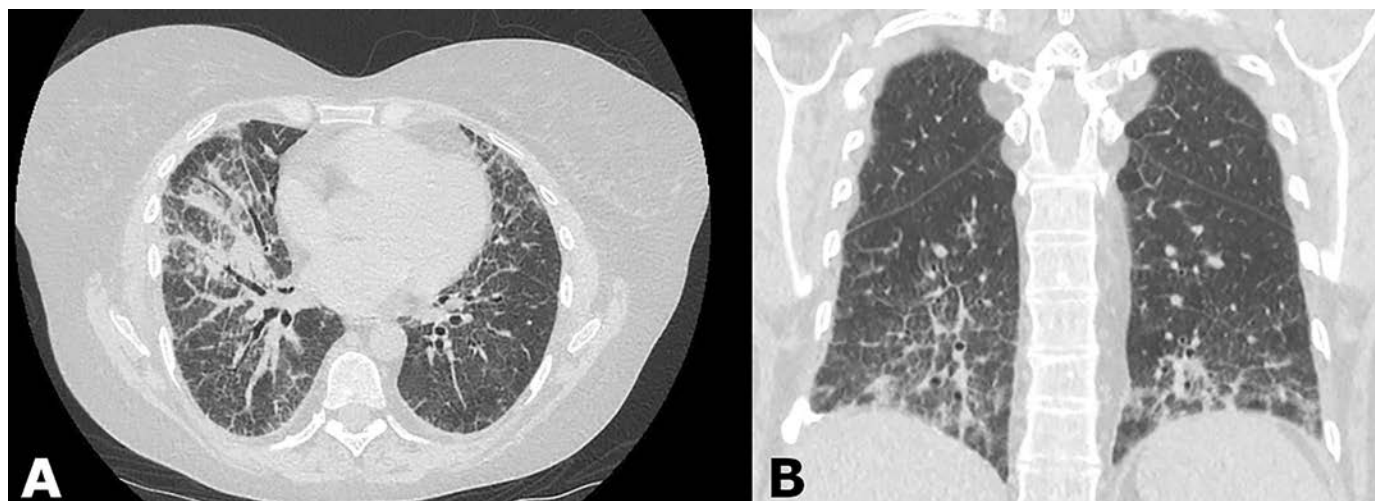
High-resolution computed tomography scan of the chest. (A–B) Chest computed tomography showed diffuse lung disease, predominant in lower and middle lobes with septal thickening involving the periphery of several lobes, some adjacent ground-glass opacities, bilateral peribronchovascular thickening, and some pleural thickening.
